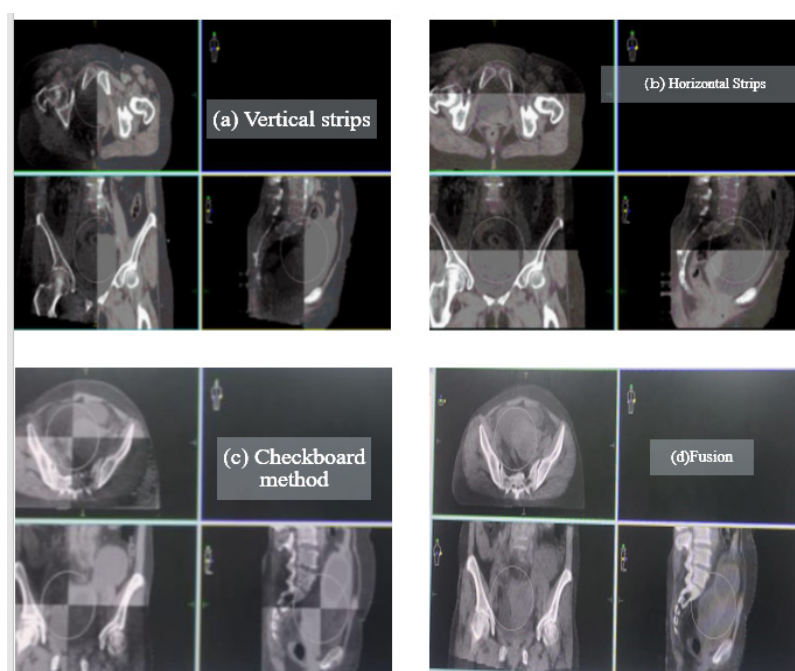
Routine CT and kVCBCT Images were Anatomically Fused
